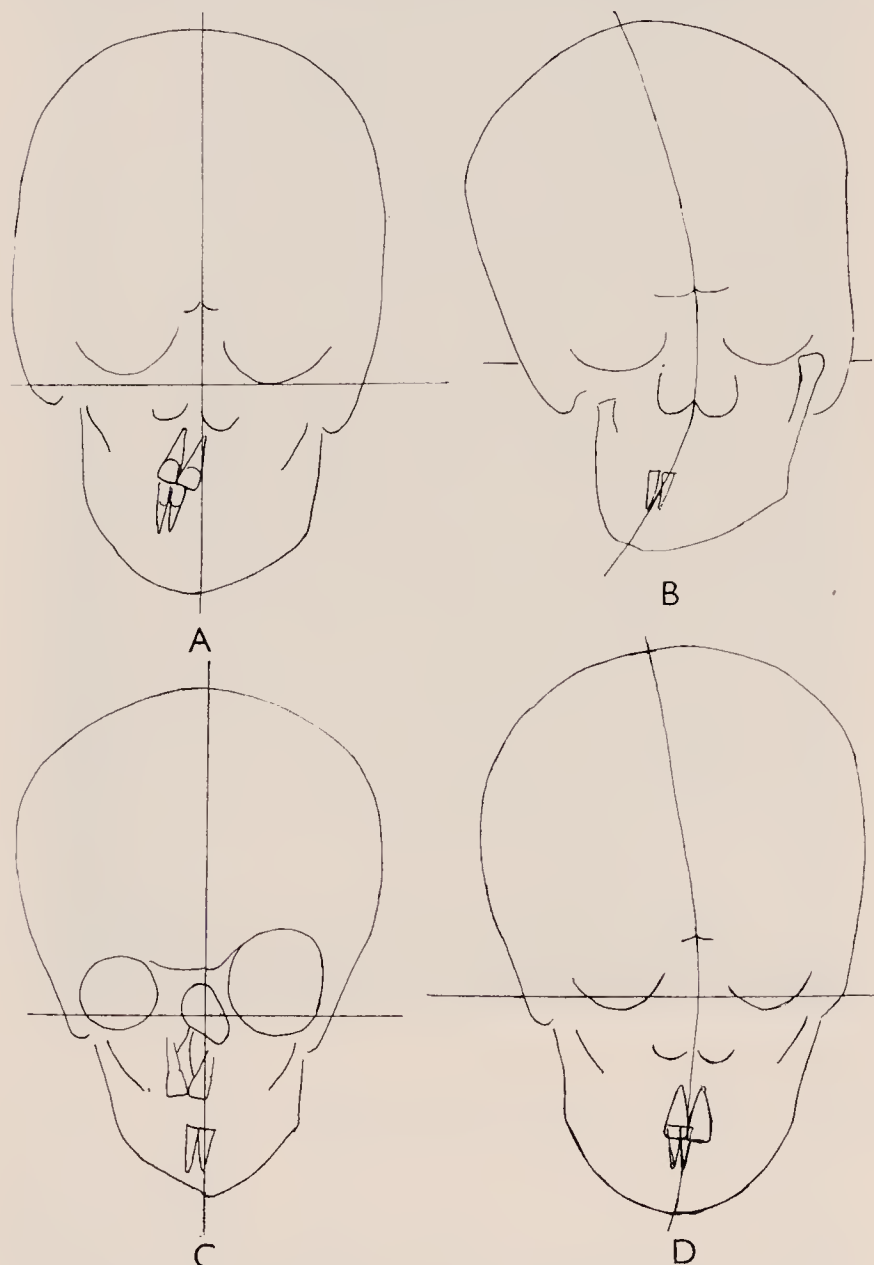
Tracings of cephalometric radiographs, the head being orientated on the Frankfurt plane showing the degree of craniofacial deformity in different defects. A, Hemifacial atrophy; B, Auriculofacial hypoplasia; C, Anophthalmia right eye; D, Muscular torticollis.
